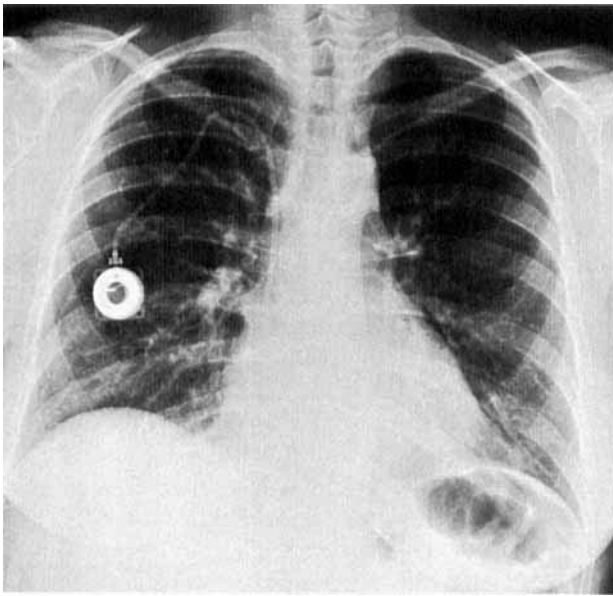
Case report 1. Postoperative chest X-ray, documenting a proper position of the catheter without pinch-off sign.
